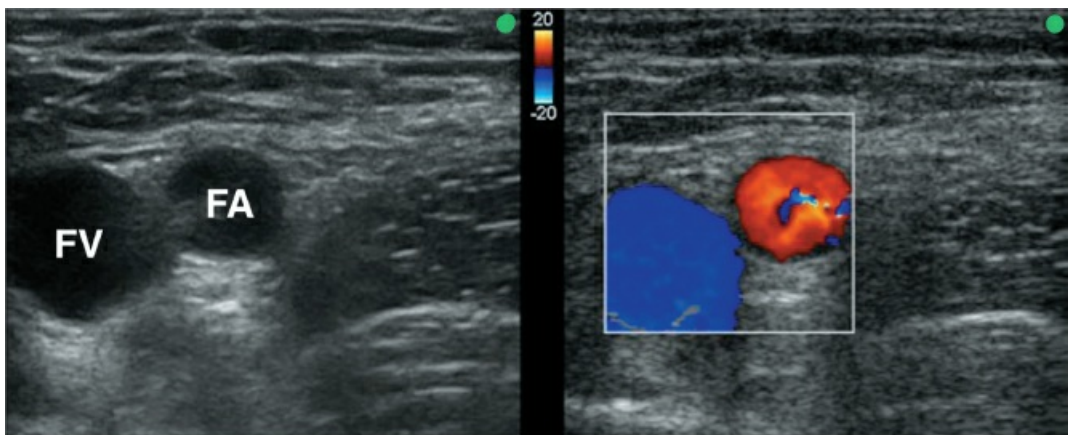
Color flow Doppler imaging for identifying arteries and veins. The image on the left is a short-axis view of the femoral artery (FA) and femoral vein (FV) in the groin, and the image on the right is a color Doppler image of the same blood vessels showing the artery in red and the vein in blue. The green dots mark the lateral side of each image.
